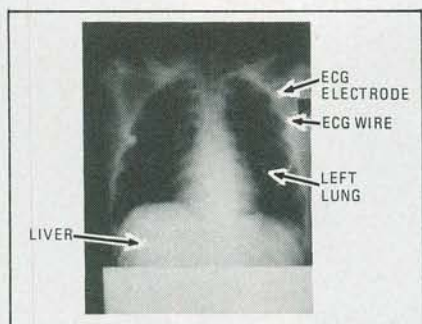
A CHEST X-RAY. Since air allows the maximum amount of X-rays to reach the film, the lungs show up as a dark area.
